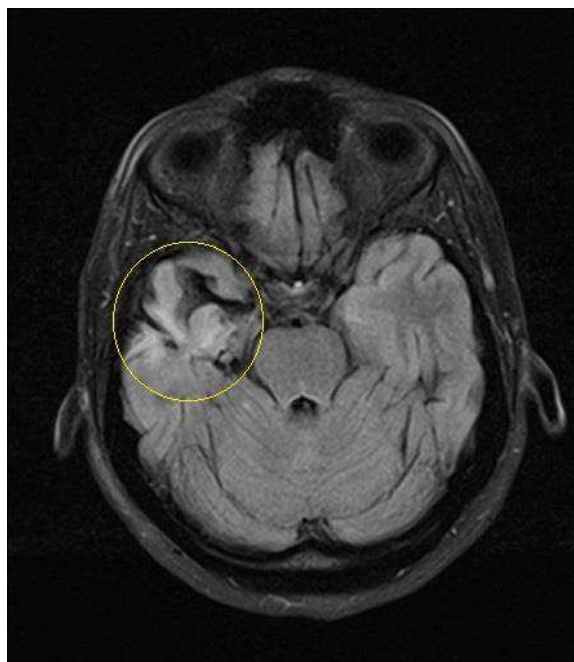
MRI flair sequence. Axial view. Right temporal lobe atrophy. Gliosis.
